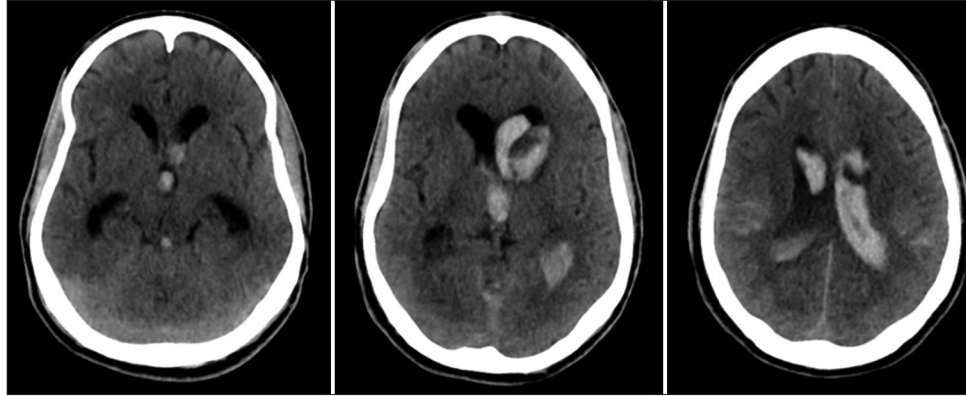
The axial computed tomography scan revealed that both lateral ventricles were inundated; however, the clot was more prominent on the left side once the hemorrhage originated at the left head of the caudate nucleus. It is also remarkable that the hemorrhage extended to the third ventricle.
